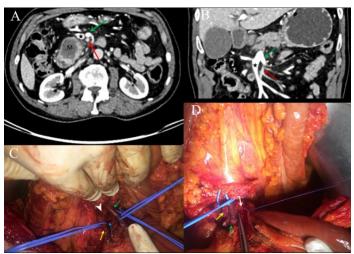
A 63 year-old man with pancreatic head tumor. Axial (A) and coronal (B) CT images show first jejunal trunk (green arrows) crossed anteriorly to the SMA (red arrows) and merged with large ileal branch (black star). Note the necrotic mass lesion of the head of the pancreas (M) with lack of invasion of SMV and SMA. Intraoperative photographs (C), (D) show exposure of the SMA, SMV and its first-order branches by dissecting the mesenteric root. Note the anterior coursing first jejunal branch (green arrows). White arrowhead indicates the lack of a main SMV trunk that ileal (yellow arrows) and jejunal branches joining at splenoportal confluence. Blue and white arrows depict early ligation of IPDA and ligation of the 1 st jejunal artery, respectively.
